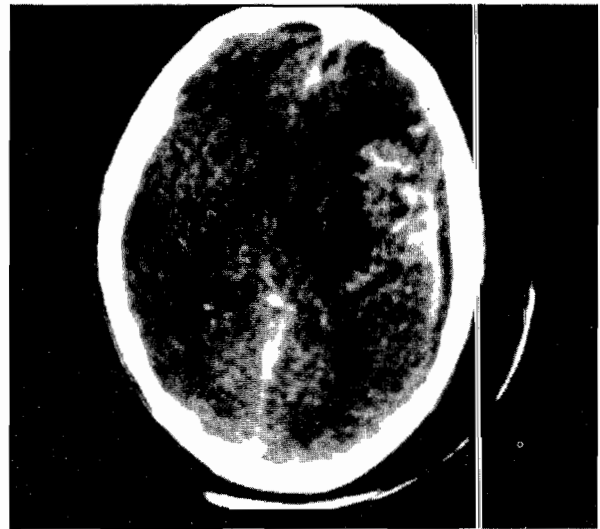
Post-contrast axial brain CT scan showing a left subdural abscess. There is mass effect with a shift of the midline contralaterally. Arrow points to a small epidural abscess along the interhemispheric fissure anteriorly.
